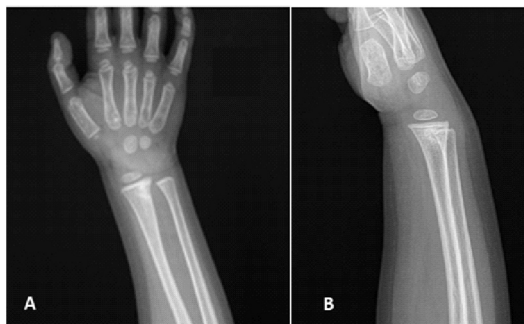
X-rays at 45 days from the onset of the symptomatology. A) anteroposterior view, B) lateral view. The lytic lesion disappeared. The lesion is filled by a tissue with a signal very similar to normal bone (Rinonapoli G, 2016)
